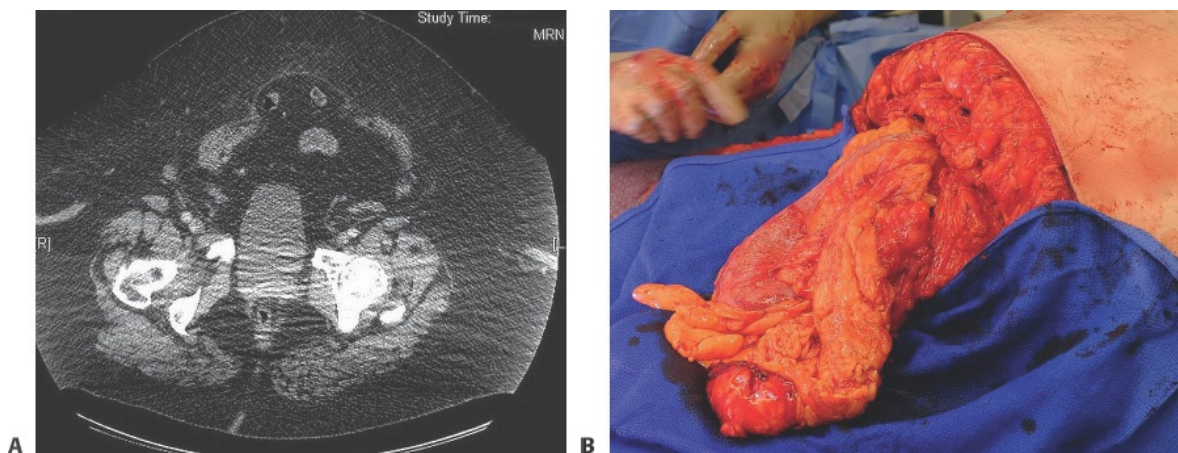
• A. Presence of hernia on CT scan. B. Intraoperative view of hernia.
